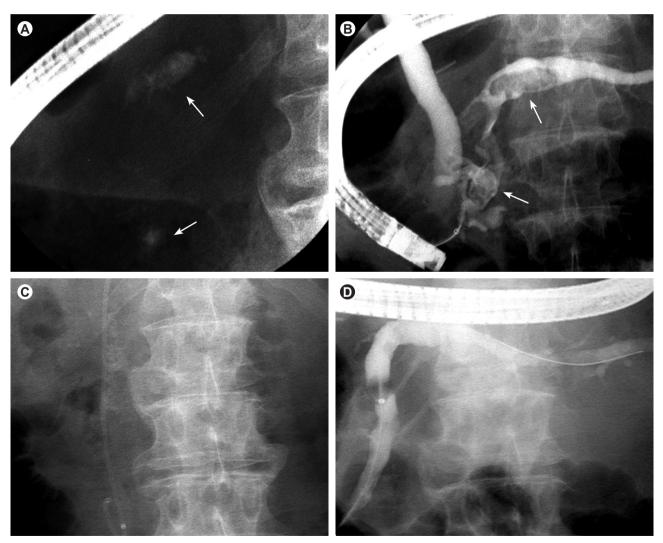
Extracorporeal shock wave lithotripsy (ESWL) to facilitate removal of pancreatic duct stones. (A) Two pancreatic calcifications (arrows) are seen on the plain film. (B) Two filling defects (arrows) were observed in the main pancreatic duct, which were difficult to remove due to their large size. (C) Radiopaque stones seen alongside the pancreatic stent were fragmented successfully after ESWL. (D) Fragmented pancreatic stones are removed by sweeping using a retrieval balloon.
